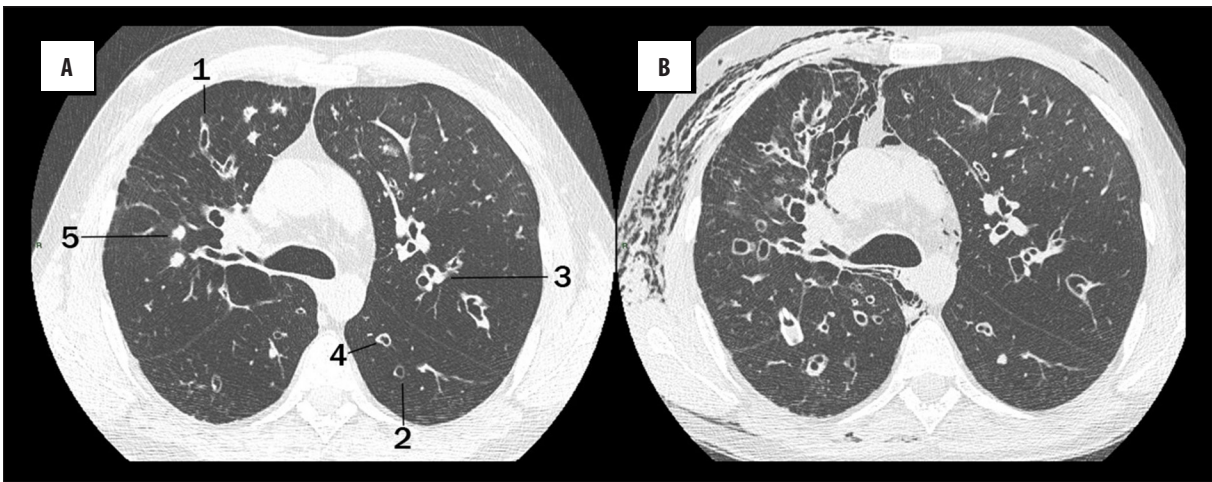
(A) The diagnosis of bronchiectasis on inspiratory computed tomography images can be based on the following findings: lack of normal tapering of the bronchial lumen (1), visibility of airways in the peripheral lung (2) and lumen of the bronchi larger than the lumen of the accompanying pulmonary artery (3), which can be observed as a signet-ring sign. These images also show other CF signs: airway wall thickening (4) and mucus plugging (5). (A, B) HRCT scans present progression of the disease tracked by computed tomography in a 28-year-old man. The interval between (A) and (B) examination was two years. A substantial progression of bronchiectasis and airway wall thickening coexisting with complications in the course of the disease such as subcutaneous emphysema and pneumomediastinum.
